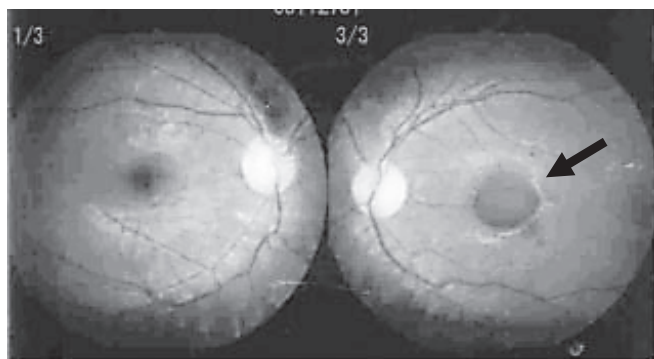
Computed tomography (CT) images and a fundoscopic examination of Case 1. (3a) After 10 days of chemotherapy, abdominal CT revealed submucosal bleeding of the intestine and obstructive ileus in cross-sectional images. (3b) After 16 days of chemotherapy, a fundoscopic examination revealed a left submacular hemorrhage (arrow).
